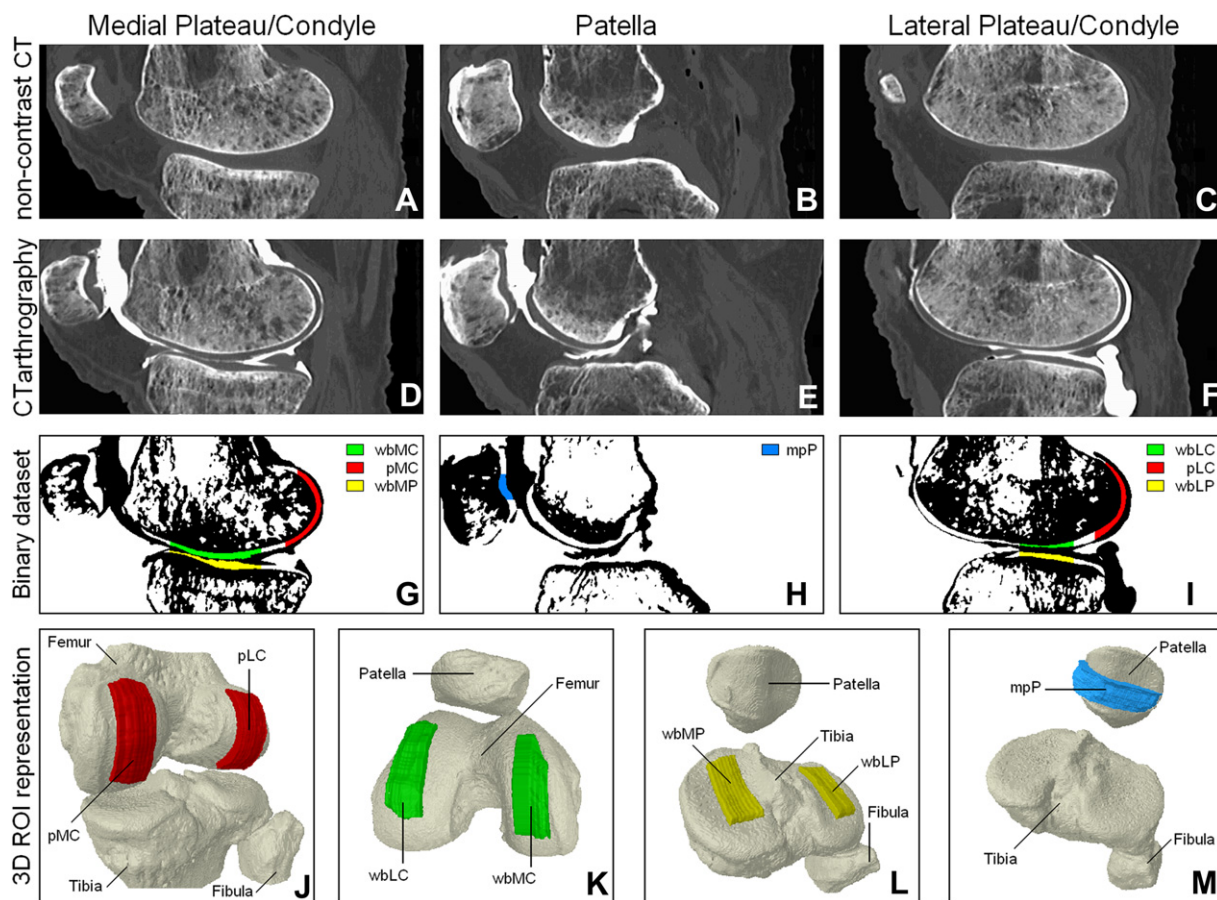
Representative sagittally reconstructed images of a knee joint from ncCT (A–C) and after intra-articular contrast injection for CTA (D–F), after segmentation into a binary dataset showing the definition of the ROIs. (G–I), and a 3D representation of all seven analyzed ROIs (J–M): weight-bearing medial and lateral condyle (wbMC/wbLC); posterior medial and lateral condyle of the femur (pMC/pLC); weight-bearing medial and lateral plateau of the tibia (wbMP/wbLP); mid portion of patellar cartilage (mpP).
